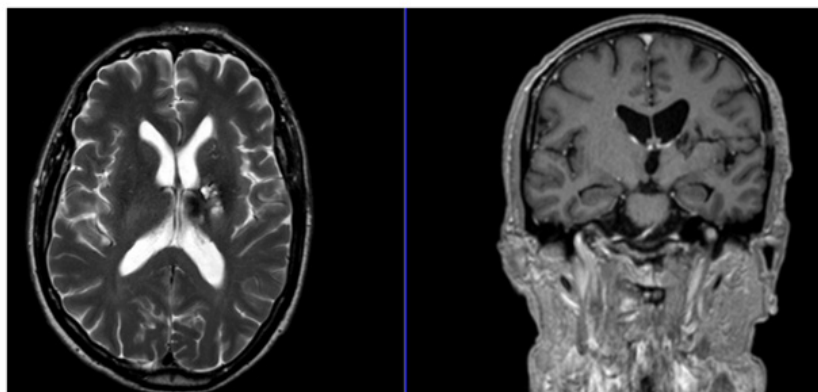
MRI revealing sequels of supported brain abscess.
